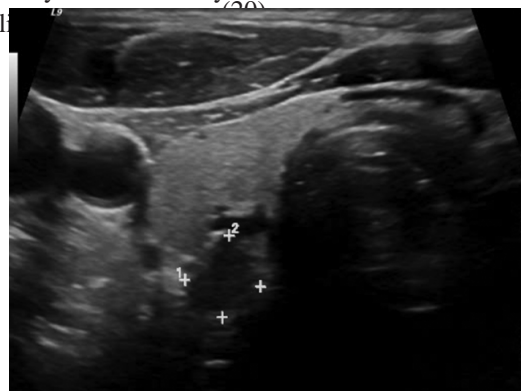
Ultrasound demonstration of a parathyroid adenoma
